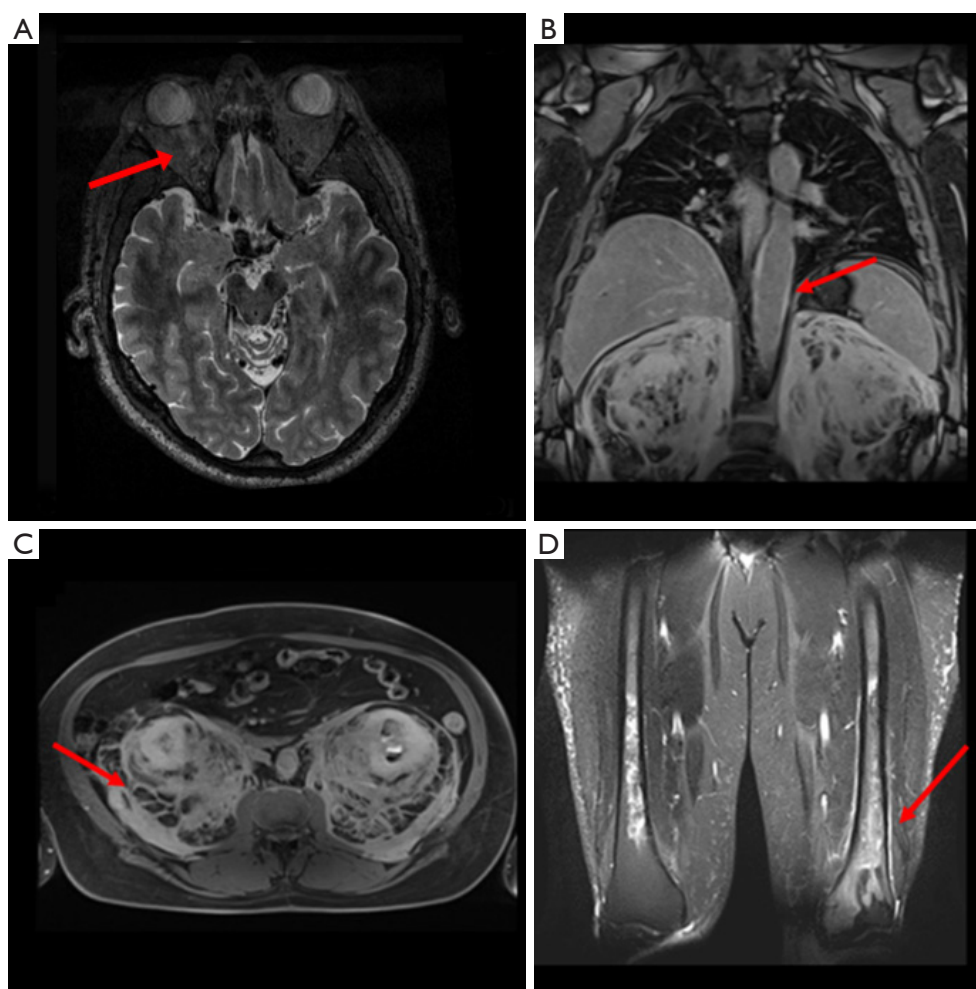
Whole body MRI findings in Erdheim-Chester disease (ECD). (A) Volumetric sequence showing mild inhomogeneity of retro-orbital fat (red arrow); (B) Coronal T1-weighted image after e.v. contrast injection showing a longitudinal concentric thickening of the aorta wall, known as *coated aorta sign* (red arrow); (C) Abdominal axial T1 showing diffuse inhomogeneity of the perirenal space, known as *hairy kidney sign* (red arrow); (D) coronal STIR image showing medullary sclerotic lesions of both the femurs (red arrow).
